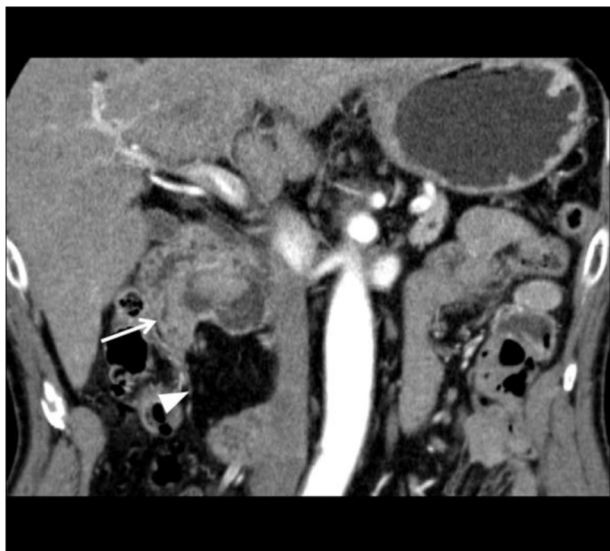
Contrast CT of the abdomen in the coronal view. The mass consists of an IPMN-like lesion (arrow) and a lipomatous lesion (arrowhead).
